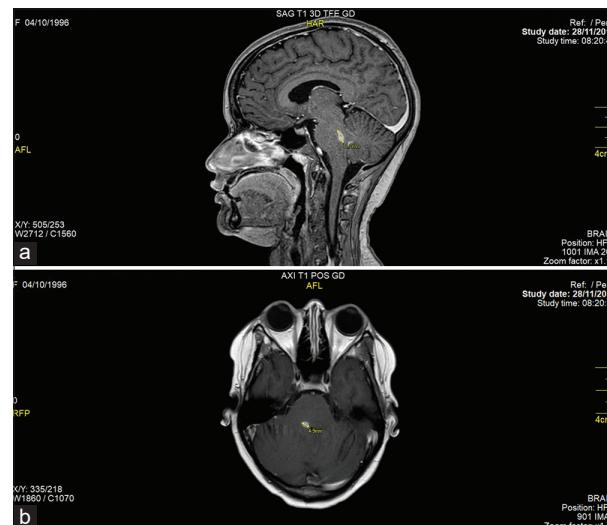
(a) Magnetic resonance imaging showing contrast (gadolinium) lesions in the pons and midbrain in the sagittal orientation after antibiotic treatment. (b) Magnetic resonance imaging showing contrast (gadolinium) lesions in the pons and midbrain in the axial orientation after antibiotic treatment.
